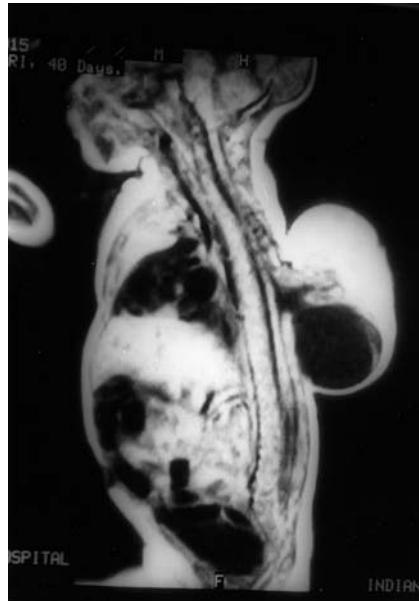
MRI sagittal sections showing a large, partially cystic lesion in the mid dorsal region with intraspinal extension
